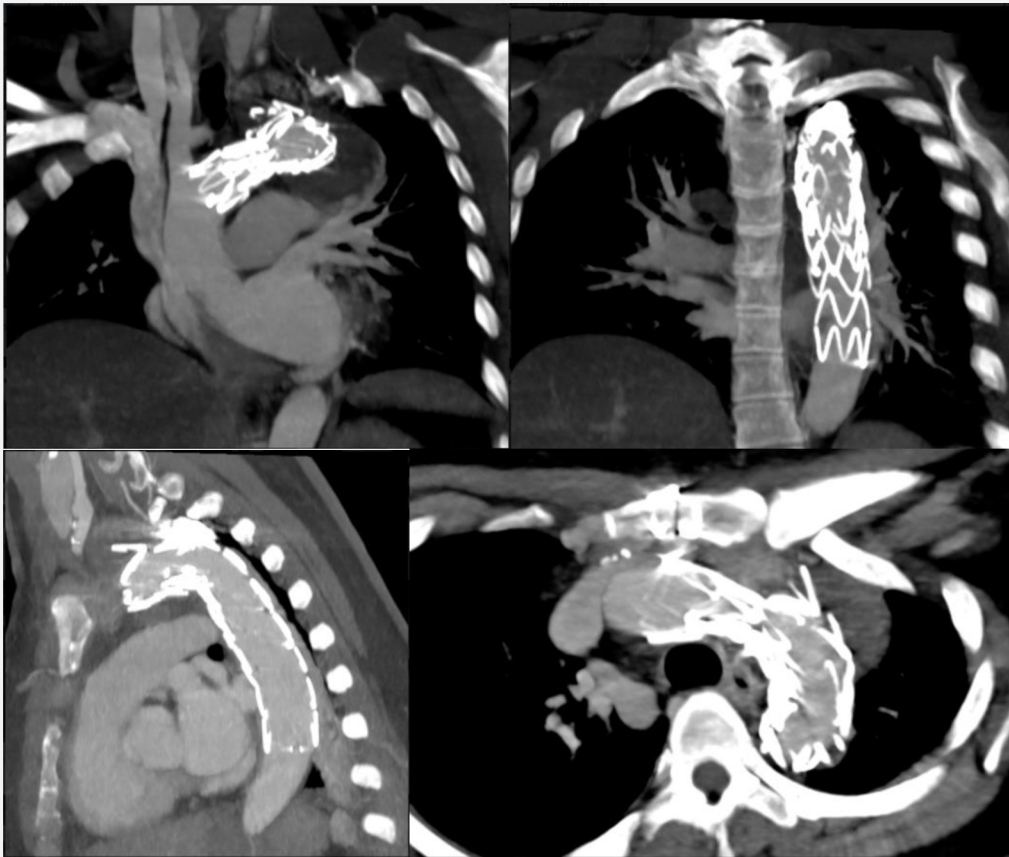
Follow-up CTA after one week demonstrating optimal repair with thrombosed aneurysmal sac, optimal graft position and no endoleaks and preservation of the cerebral circulation. Coils within the LSA are likewise stable.
